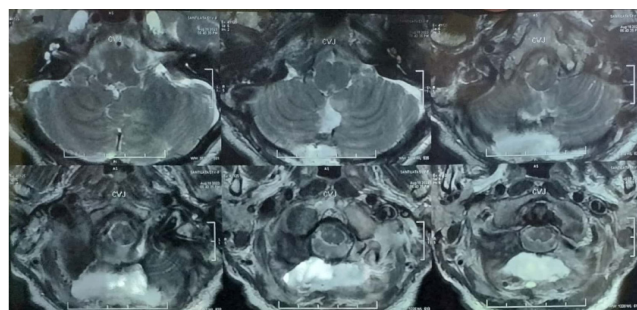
Contrast MRI showing homogeneously enhancing lesion with extension superiorly into the foramen magnum
